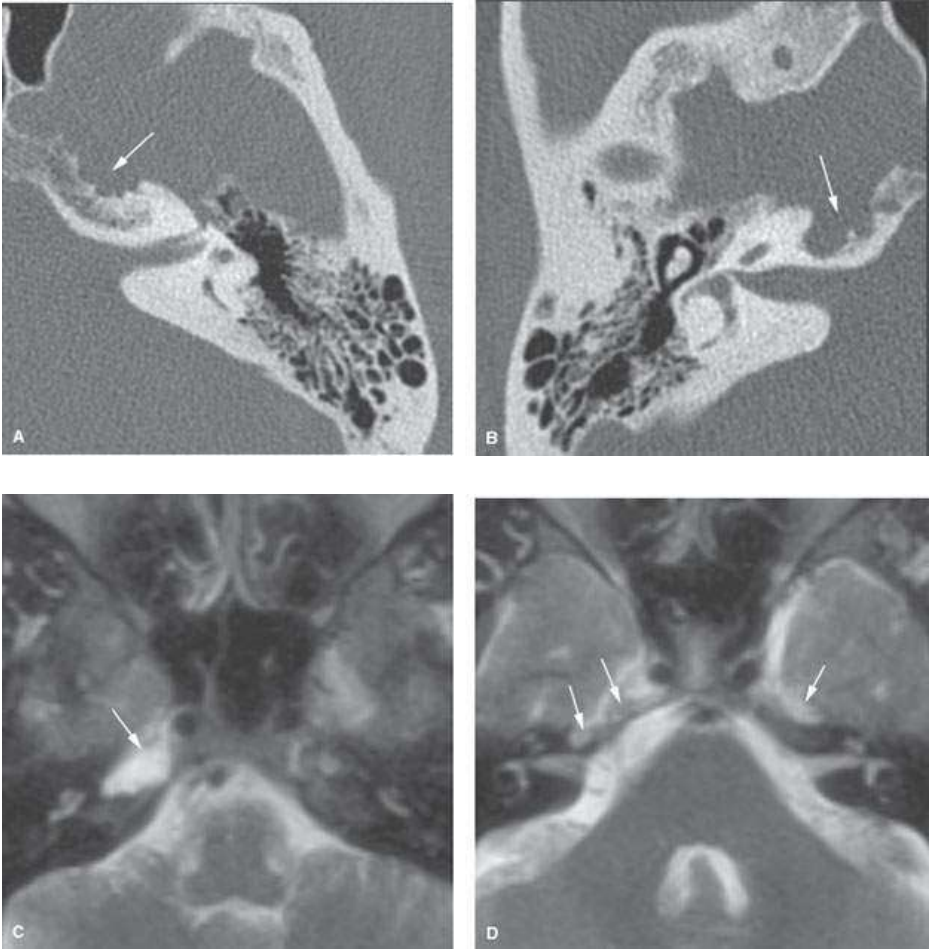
Arachnoid granulations at the petrous apex. On computed tomography (A, B), lobular, smoothly marginated defects along the anterior surface of the petrous apex are seen bilaterally (arrows). On T2-weighted magnetic resonance images (C, D), signal intensity of cerebrospinal fluid is seen at this level, confirming that the remodeling is due to arachnoid granulations (arrows).
